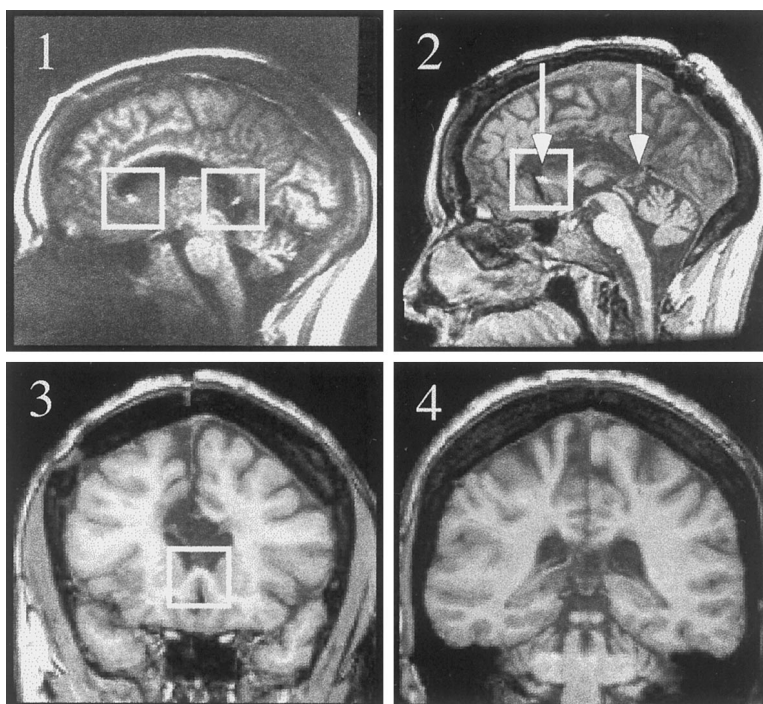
Images taken from MRI scans of the patient taken in 1984 and 2000. The white squares mark regions of bright signal observed at both ends of the corpus callosum in the 1984 scan (panel 1), and at the rostral end in the 2000 scan (panel 2). The arrows in panel 2 indicate the locations of the coronal slices shown in panels 3 and 4. Panel 3 shows a coronal slice through the region of bright signal found in the anterior corpus callosum in the midsagittal view. The spared callosal fibers can be clearly seen. Panel 4 shows a coronal slice taken from the posterior end of the corpus callosum, in the region where bright signal had been observed in 1984. The callosal fibers in this slice are clearly severed.
